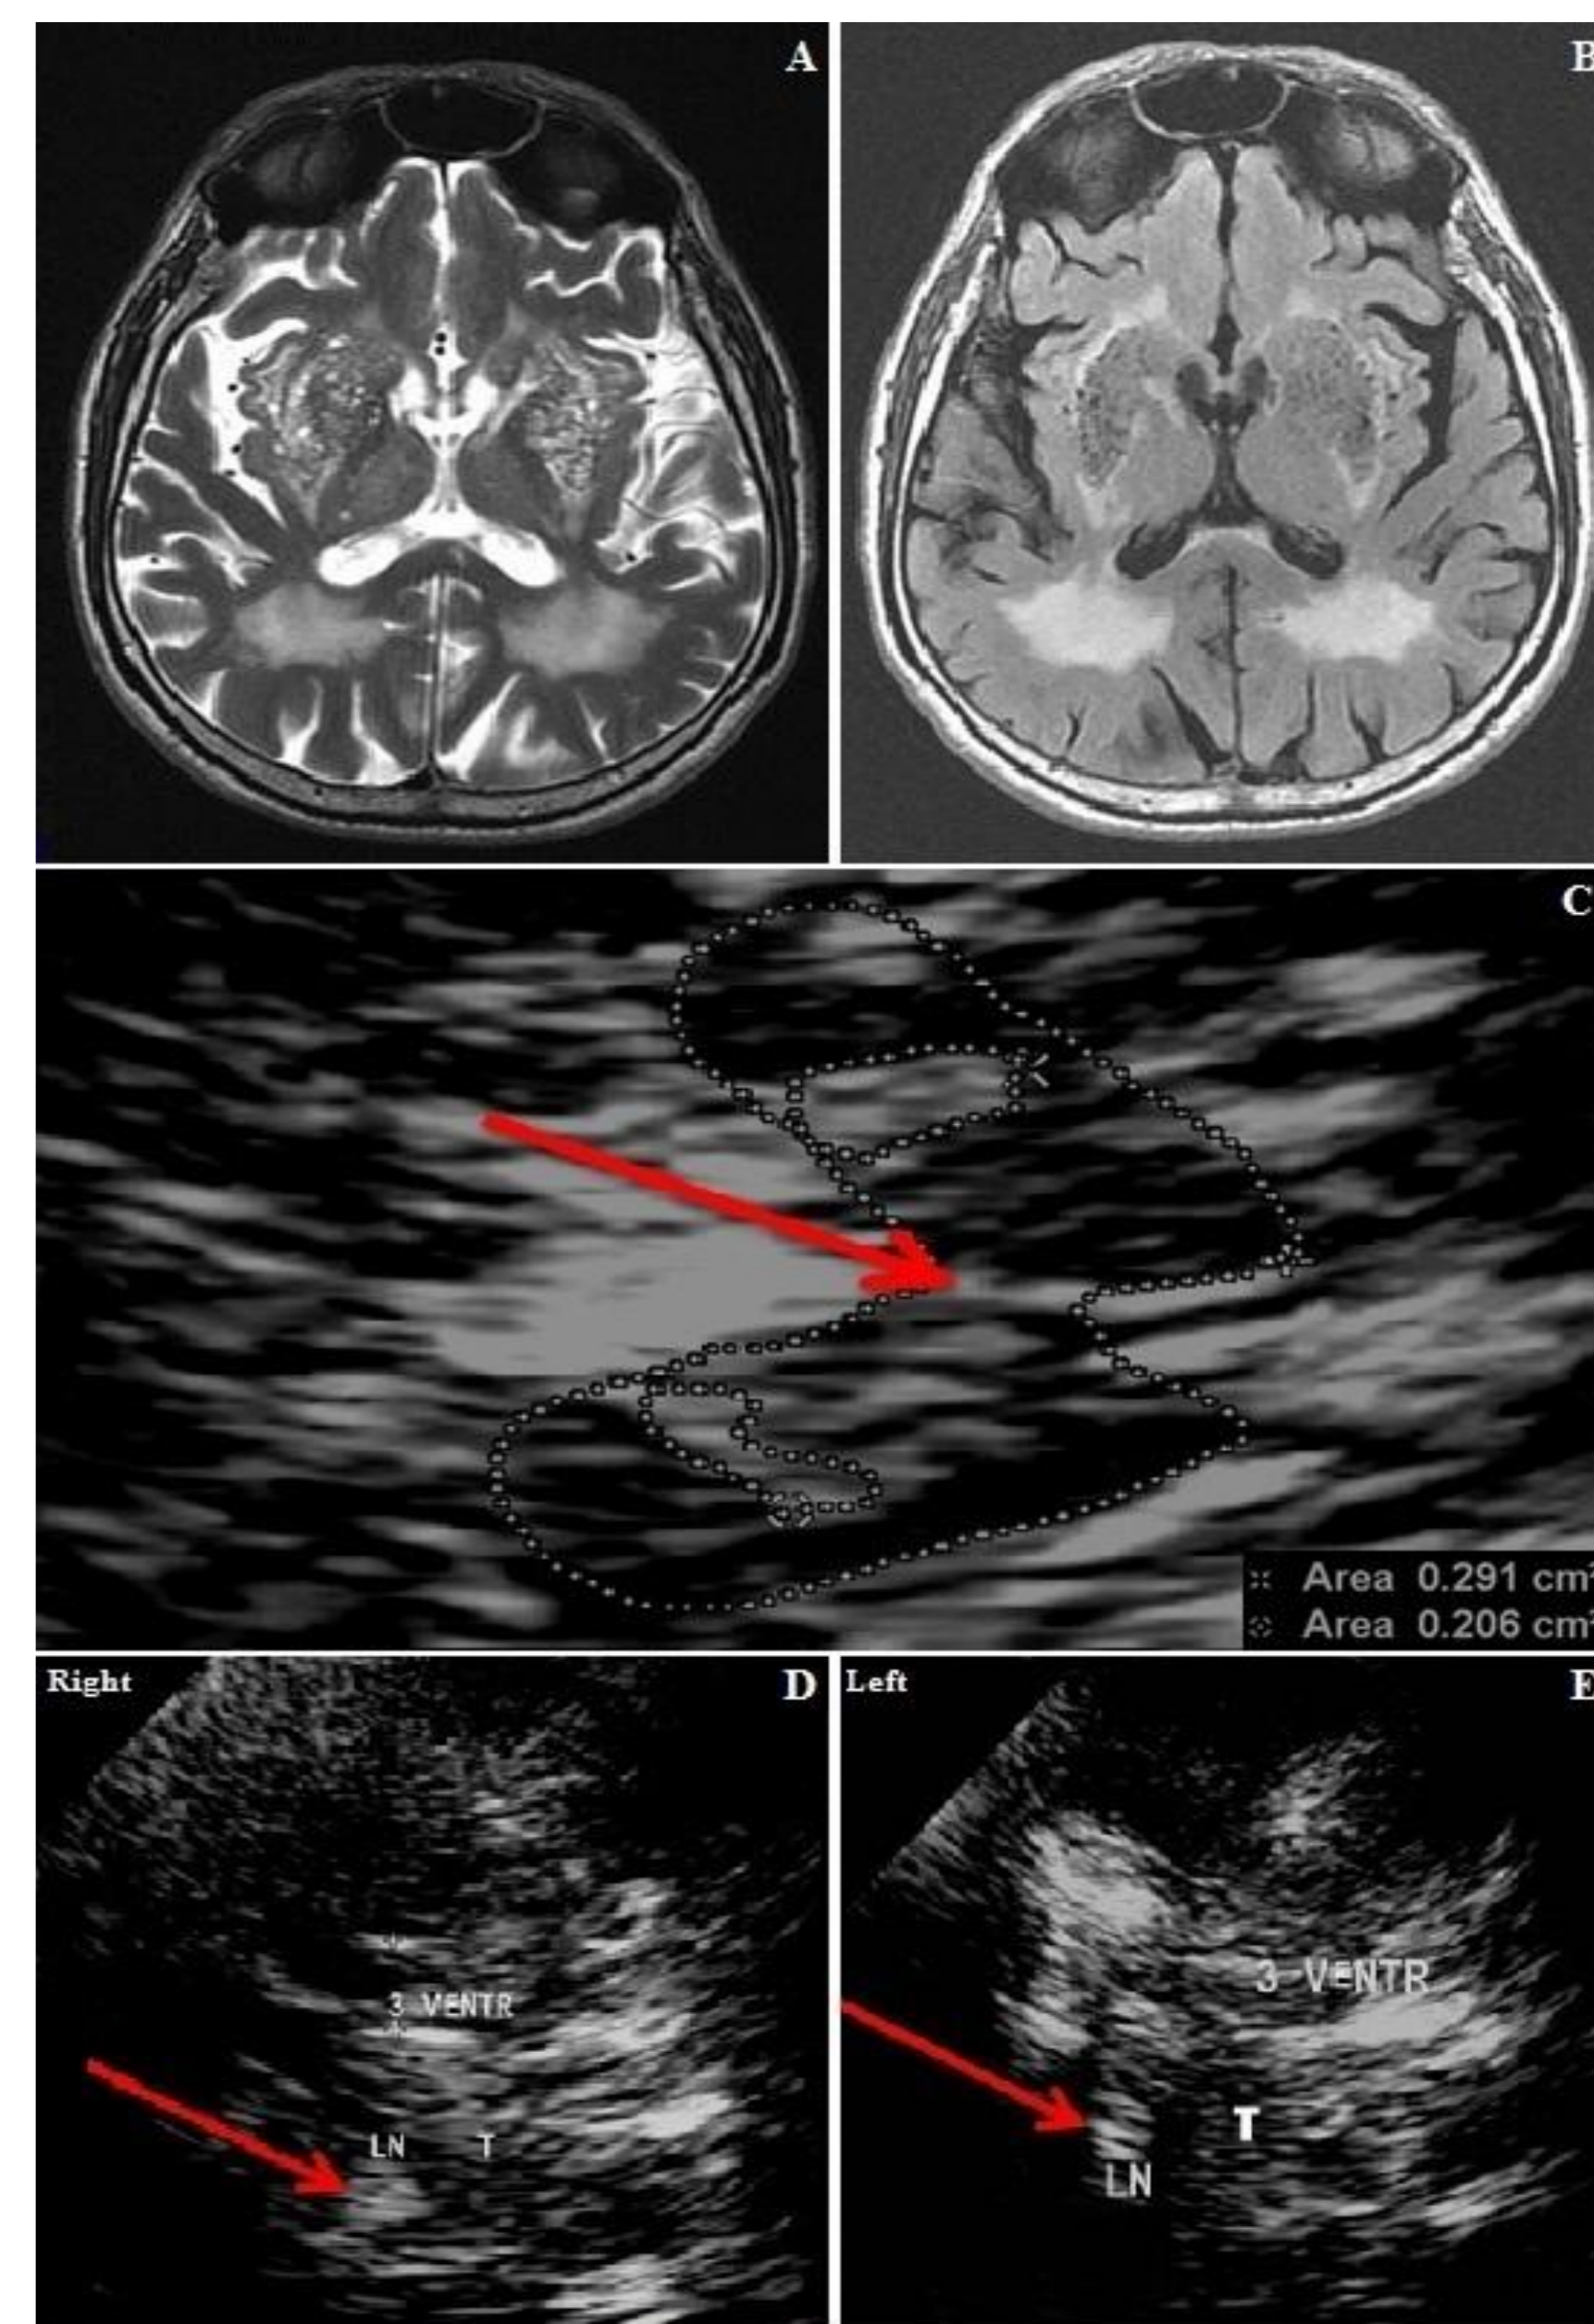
Neuroimaging and transcranial sonographic study in twin A. A-B: FLAIR and T2-weighted brain MRI images show neuroimaging features of CADASIL with confluent lesions in the external capsule and in the subcortical white matter of the frontal and temporal lobes. Vascular lesion is present in the right anterior limb of internal capsule. MRI shows also a marked cribriform state of lenticular and caudate nucleus due to lenticulostriate perivascular spaces dilation. C: Through a transtemporal right approach, the TCS image shows enlarged right and left substantia nigra hyperechogenicity (right 0.291 cm²; left 0.206 cm²); the midline raphe (red arrow) appears normoechogenic and not interrupted. D-E: Through a transtemporal bilateral approach, TCS images show bilateral hyperechogenicity of lenticular nucleus (LN - red arrows) and slight increase of the 3° Ventricle (3VENTR) width (T: Thalamus).
